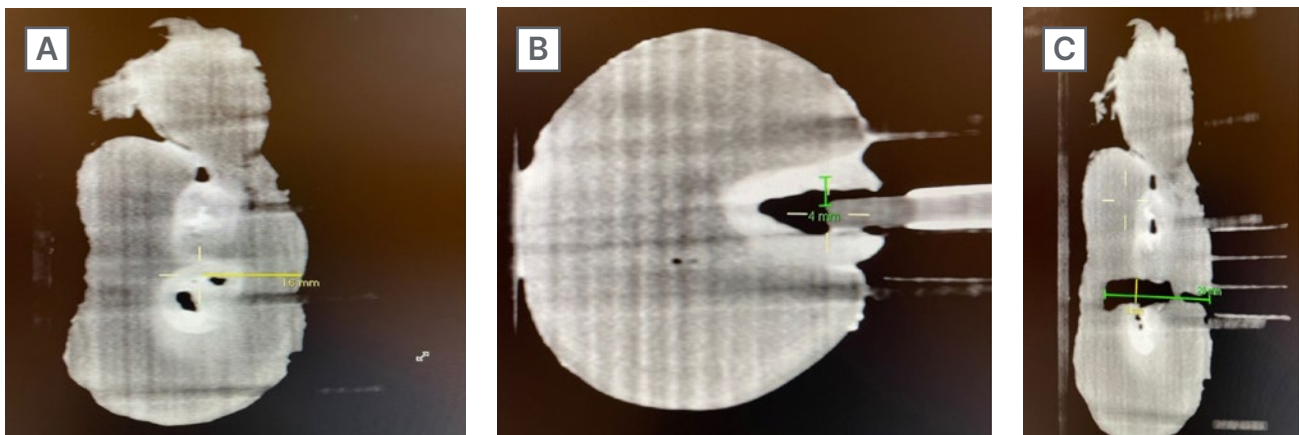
Contrast-enhanced breast CT.
